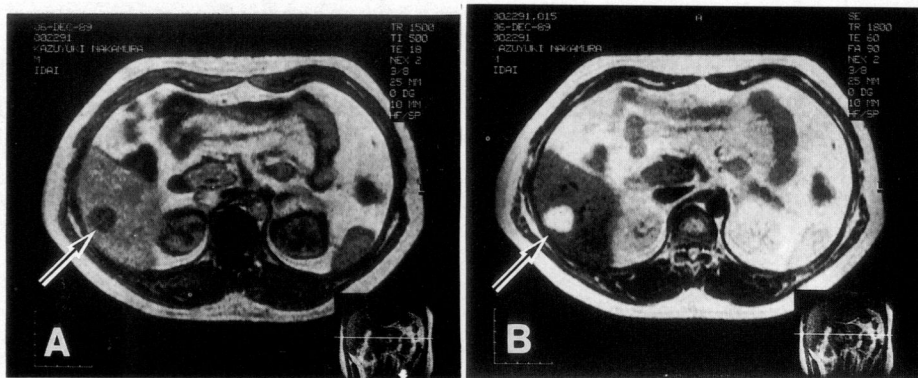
MR imaging of hepatic hemangioma.
